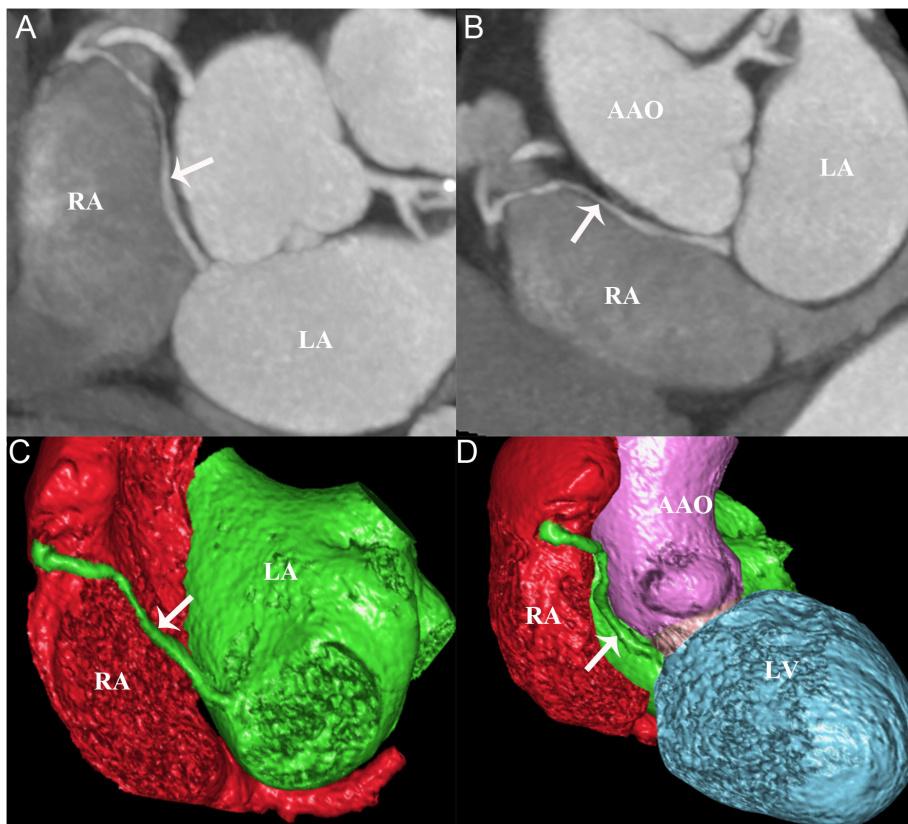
(A-B) Maximum intensity projection CTA shows an LACV that connects the anterior wall of the left atrium (LA) to the right atrial appendage (RAA). (C-D) Three-dimensional volume rendering CTA reveals that the LACV originates from the lower part of the left atrium, courses behind the aortic root, and finally drains into the RAA. AAO, ascending aorta; LA, left atrium; LACV, levoatrial cardinal vein; LV, left ventricle; RA, right atrium.
